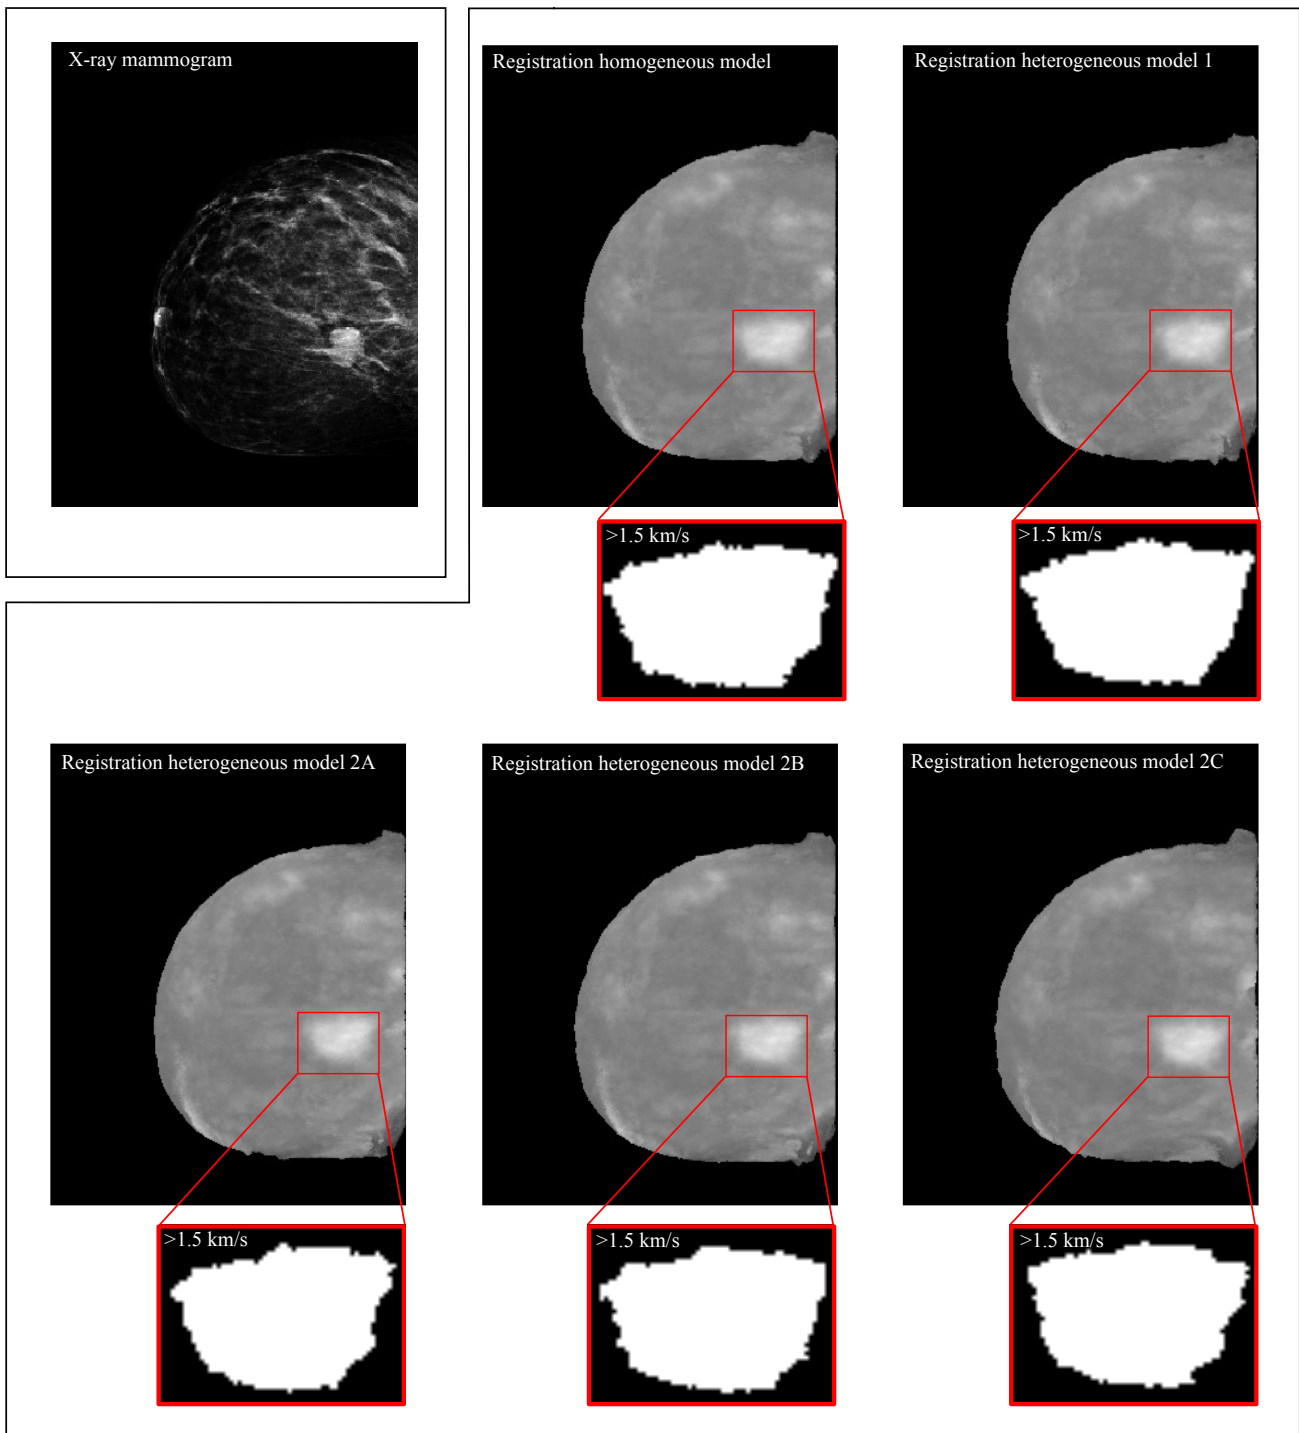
Resulting images of the registration: X-ray mammogram (top left) and maximum intensity projections of the registered speed of sound volumes using the proposed models. The enlarged images depict the lesion thresholded at a speed of sound of 1.5 km/s.
